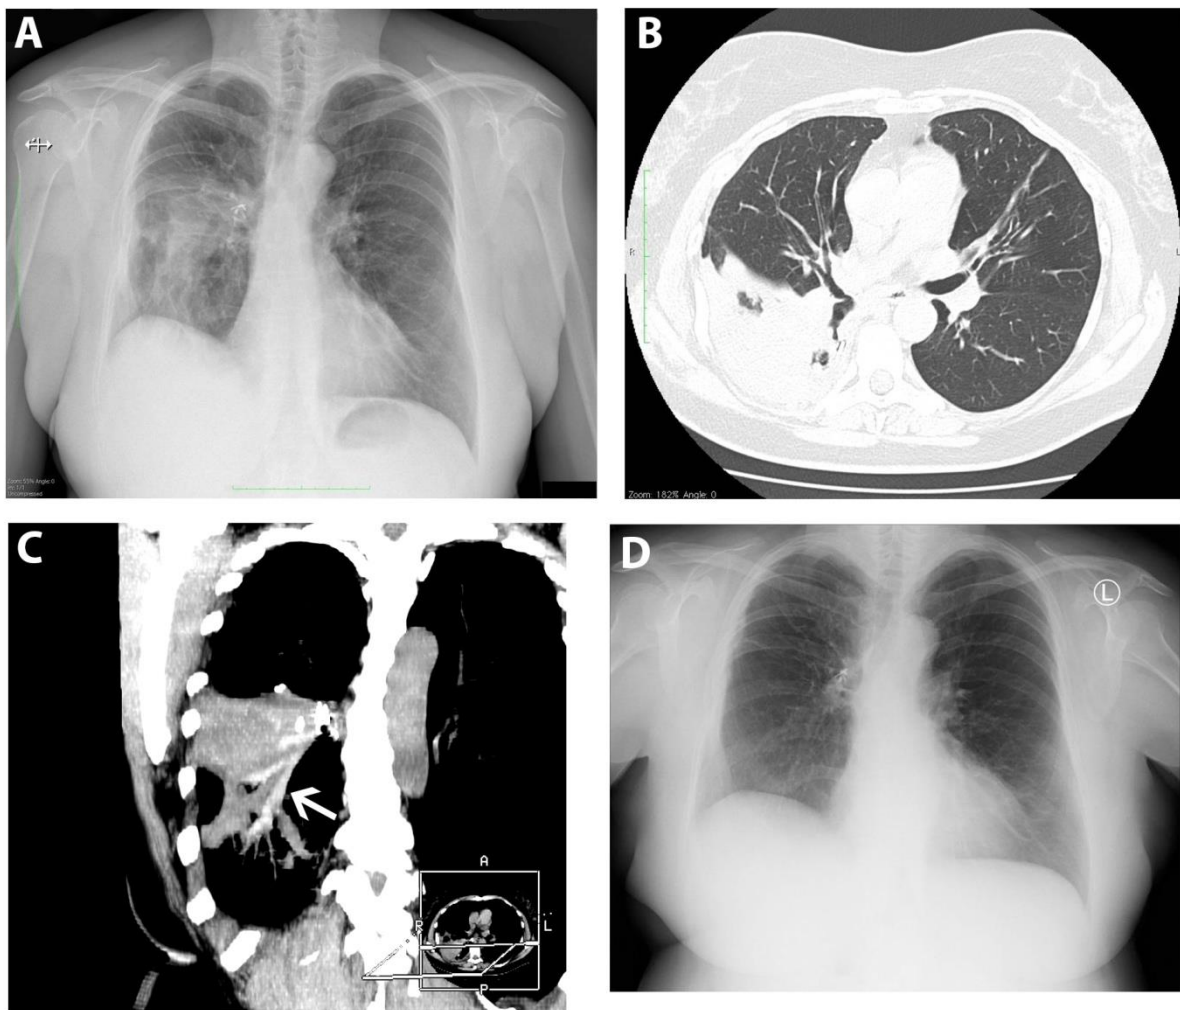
Imaging findings revealed by chest x-ray and computed tomography: opacities over middle and lower right lung field (Fig. 1 panel A and B), tubular opacities - „finger in glove” sign (panel C, arrows) and complete regression of pathological changes after treatment (panel D).
